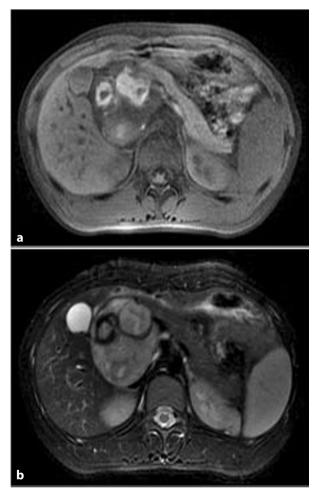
Solid pseudopapillary neoplasm (SPN). a Axial fatsaturated T1-weighted magnetic resonance image shows hypointense solid pseudopapillary neoplasm in the head of the pancreas. The internal areas of the neoplasm are hyperintense on T1-weighted images, suggestive of the presence of methemoglobin. b On the axial fatsaturated T2-weighted image, the solid pseudopapillary neoplasm appears hyperintense, with an heterogeneous pattern
